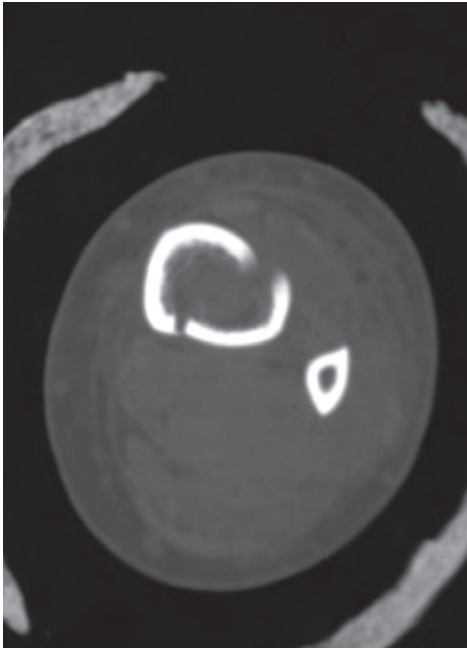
Computed tomography image revealing fracture configuration.
